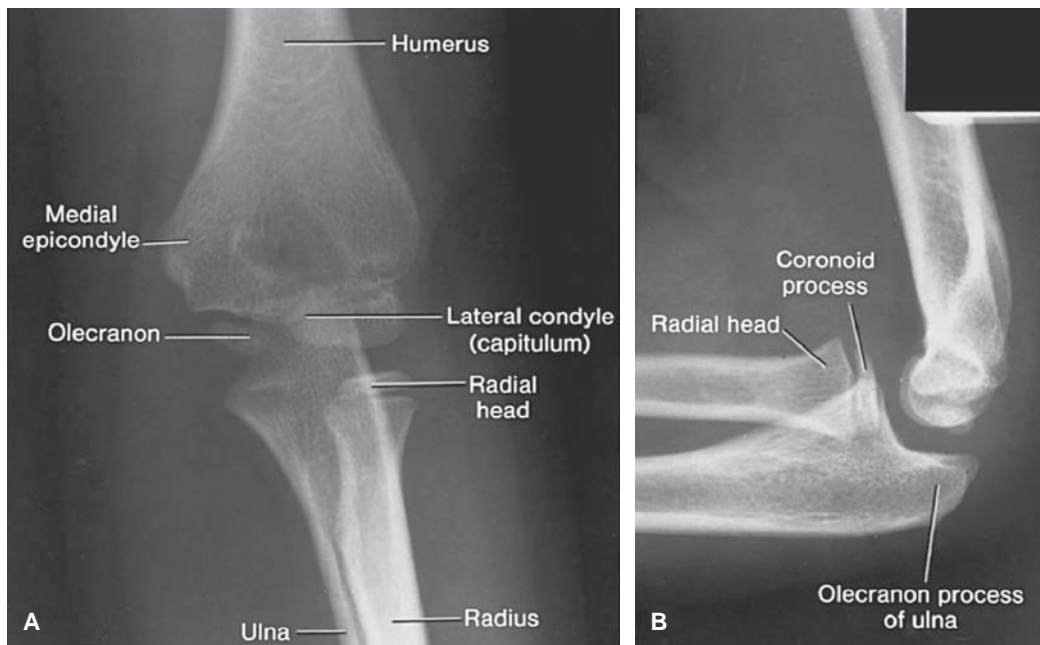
A: Anteroposterior radiograph of a normal elbow of a child. B: Normal lateral radiograph.
